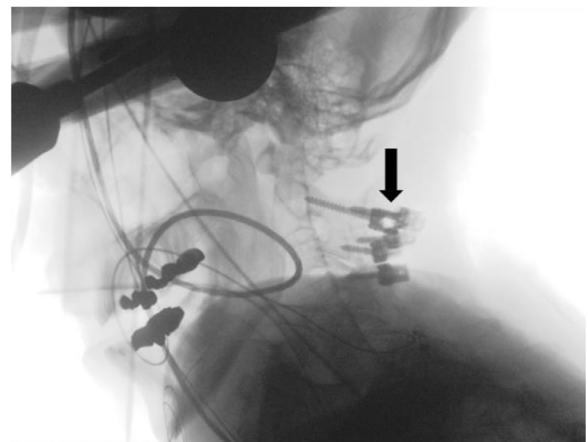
The X-ray perioperative X-ray cervical spine shows posterior fusion of the C2, C3, and C4 segments.
